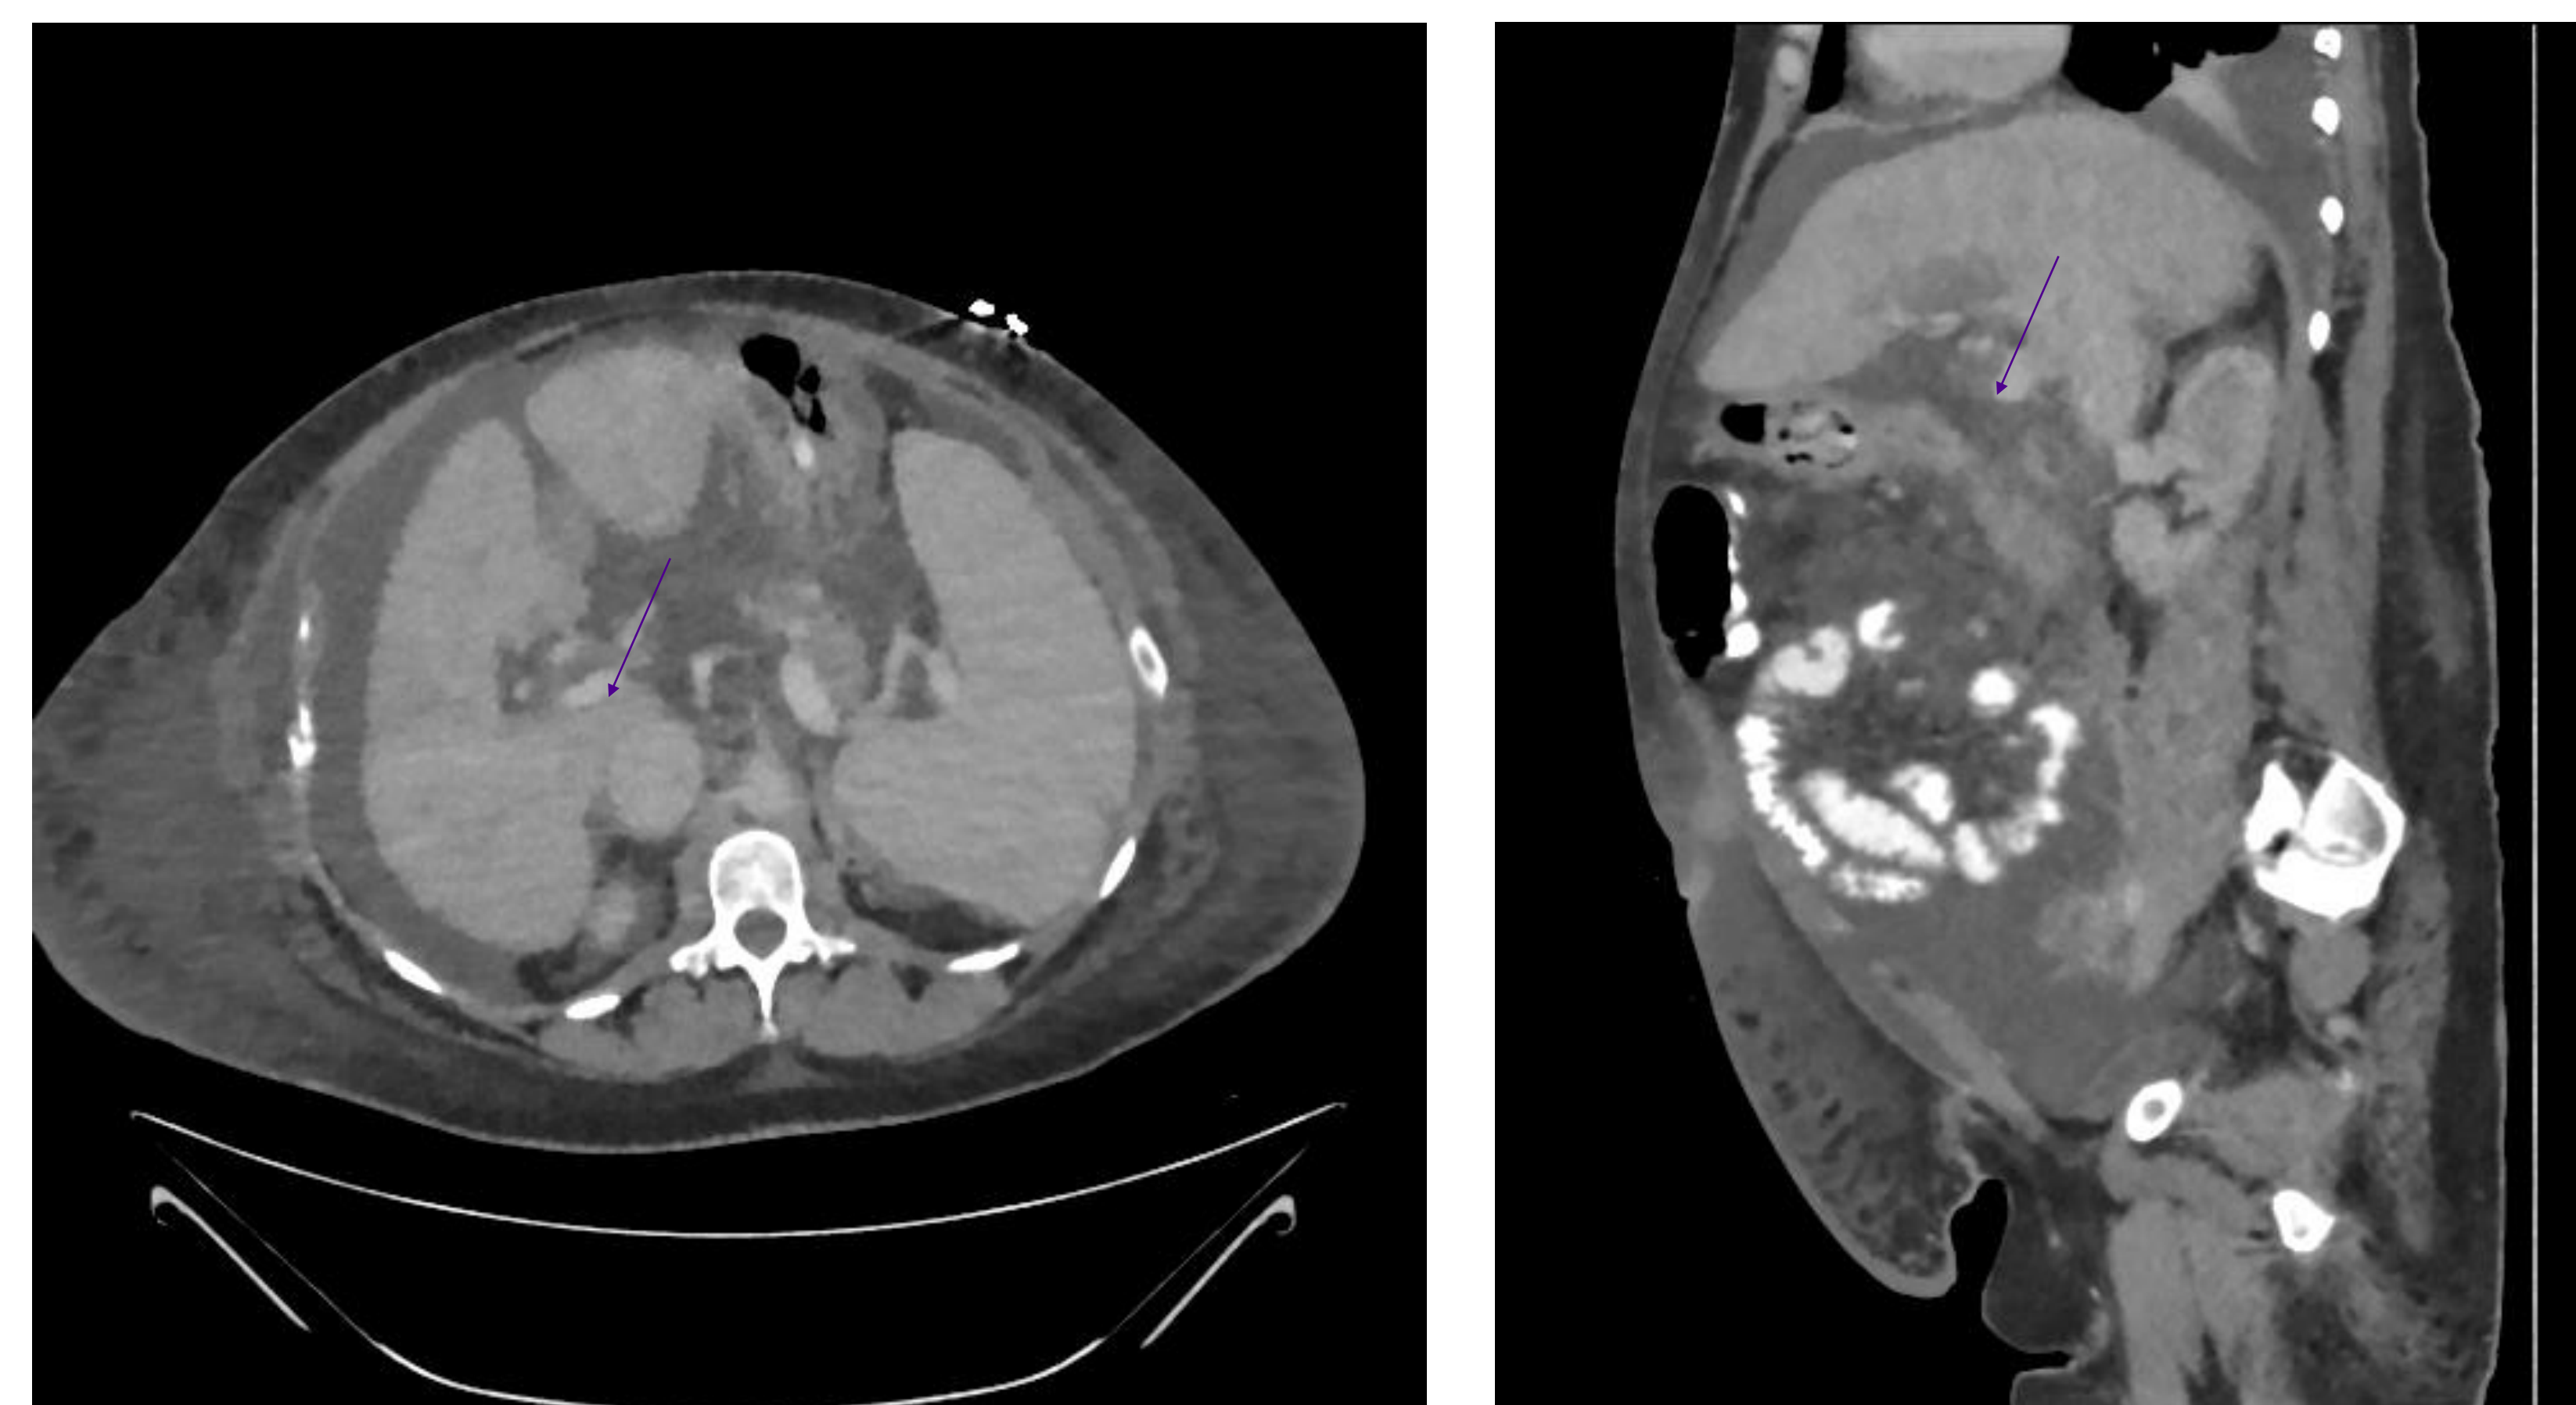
CT abdomen/pelvis with contrast showing eccentric non-occlusive thrombus in the main portal vein extending into both the right and left portal vein branches. There is recanalized paraumbilical vein.
